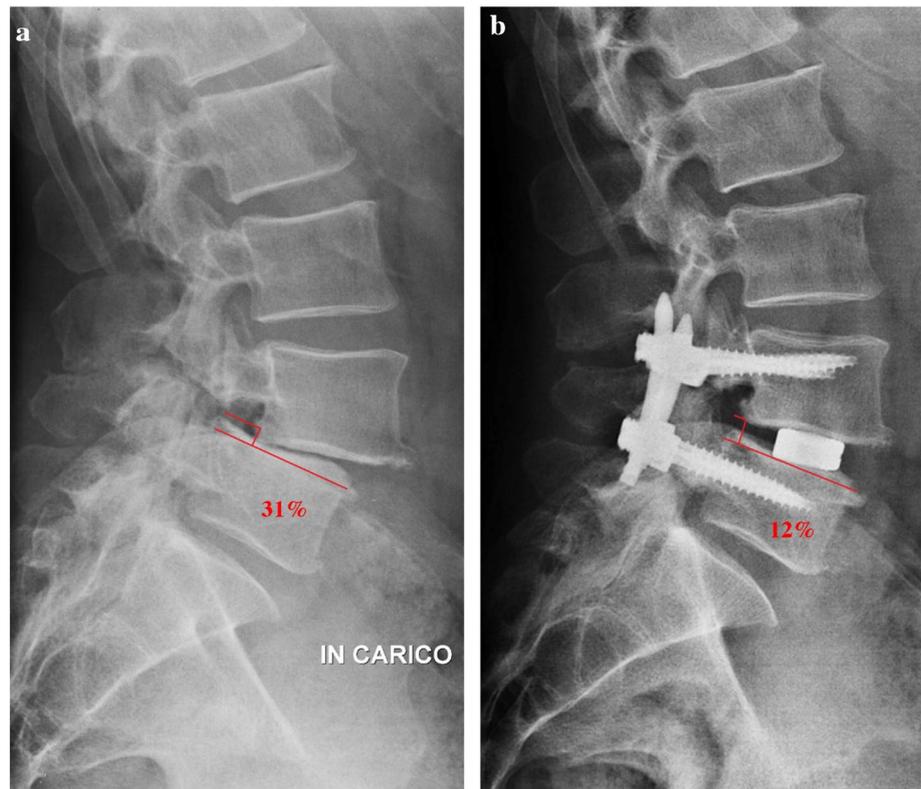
a 53-year-old man. Pre-operative lateral view X-ray of a high instability, L4–L5 isthmic spondylolisthesis with foraminal distortion due to L4 vertebral body slippage. b Postoperative lateral view shows the reduction in the L4–L5 olisthesis with restoration of the height of the intervertebral disc space and the recovery of the normal shape of the foramina
